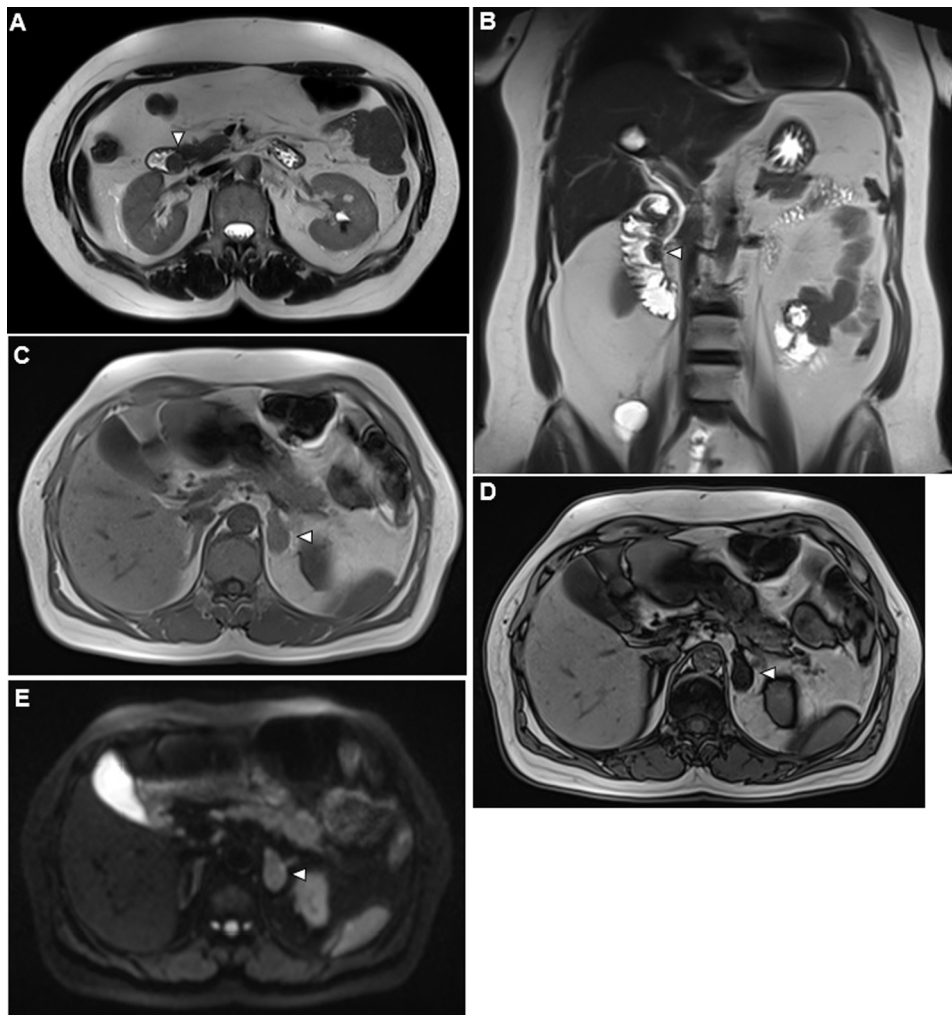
Axial (A) and coronal (B) T2 MRI shows a solid mass protruding inside the second duodenal portion at the location of the ampulla of Vater (arrowhead). This image is compatible with an ampullary tumour. MRI (C-D-E). A left adrenal lesion (arrowhead) is observed, showing signal drop between in-phase (C) and out-of-phase (D) images weighted in T1. This absence of signal indicates the presence of intracellular fat, considered diagnostic of adrenal adenoma. No restricted diffusion was demonstrated (E).
